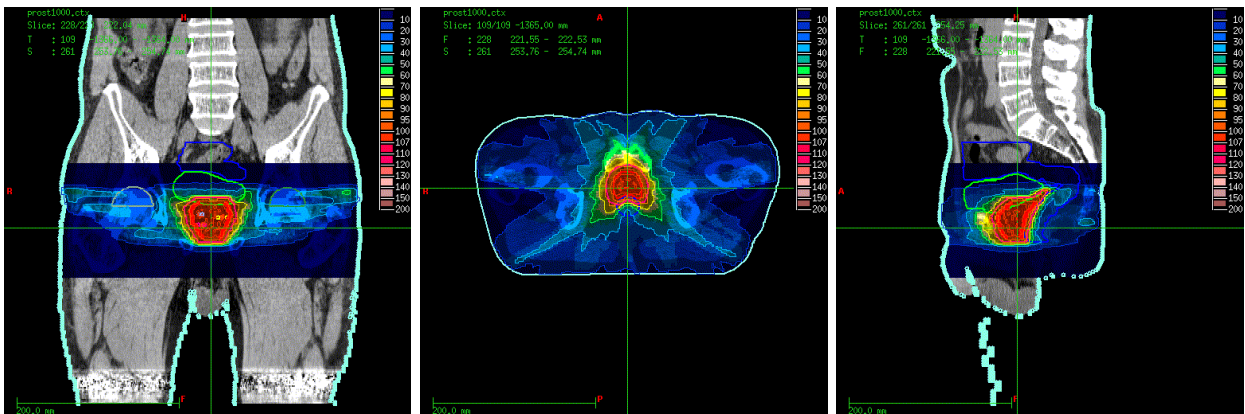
CT images of the prostate case, overlaid with the dose distribution from optimisation using the original 0 T beamlet.
